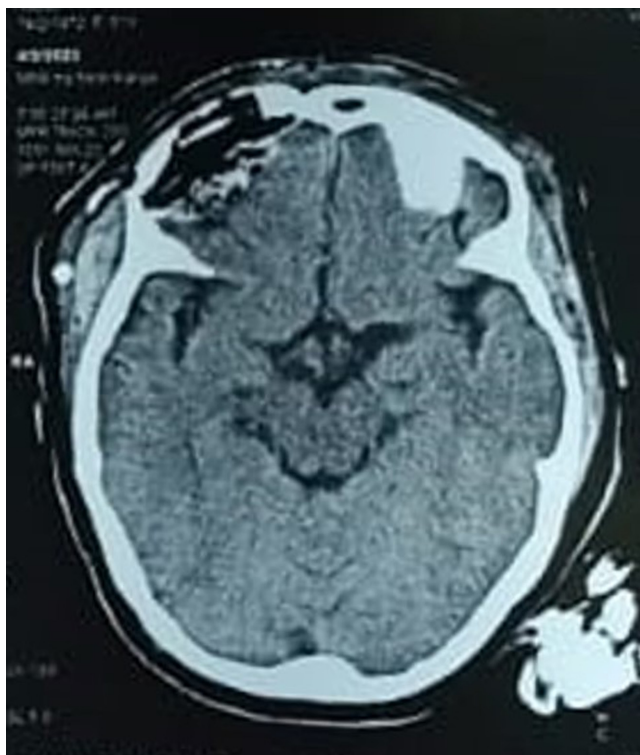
Postoperative CT scan demonstrating the successful complete removal of the schwannoma from the right superior orbit, resulting in the resolution of proptosis, and confirming the absence of residual mass.
